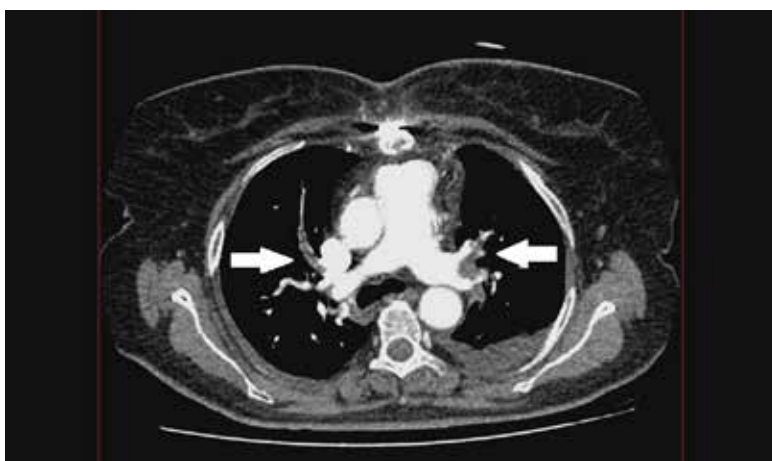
Computed tomography pulmonary angiography showing thrombi in both pulmonary artery branches and their lobar and segmental branches (arrows)
